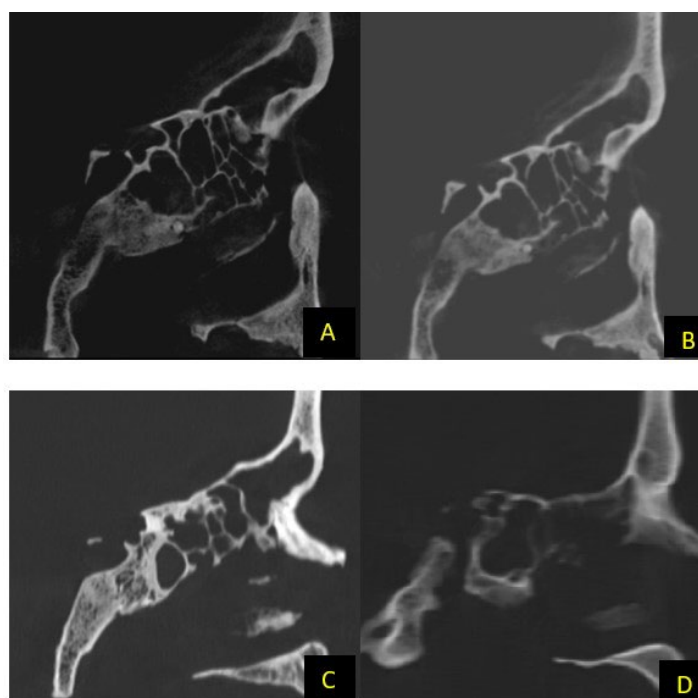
Sagittal sections; (A) high-resolution CBCT; (B) low-resolution CBCT, (C) high-resolution CT, (D) low-resolution CT
